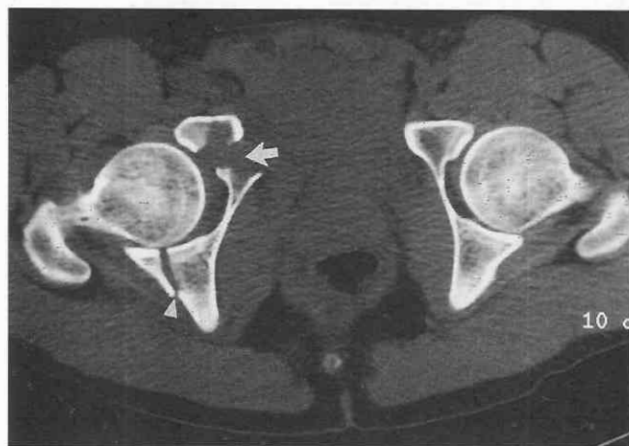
Pelvic fracture. CT scan shows a vertical fracture through the right posterior column of the acetabulum (arrow) and a displaced fracture of the anterior column (arrowhead). Only the anterior fracture was clearly shown by conventional radiography.
